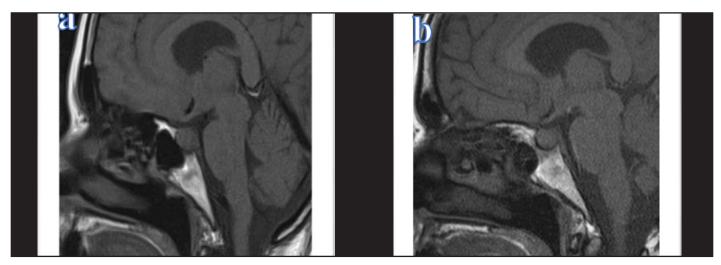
a: Before treatment, sagittal section T1 contrast-enhanced MRI b: Control MRI image, reported as normal, (1th month follow-up visit)
